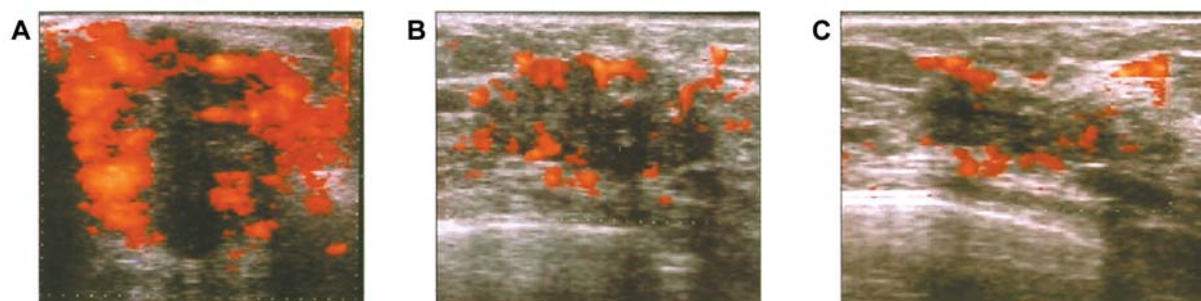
Carcinoma of the breast: color-Doppler ultrasound after Levovist injection. A) Grade 3 increase in contrast with rich intralesional and perilesional vascularization. B) After two cycles of chemotherapy: grade 2 increase compared to baseline. C) After four cycles of chemotherapy: moderate residual vascularization evident, but not evident with basic color-Doppler.
